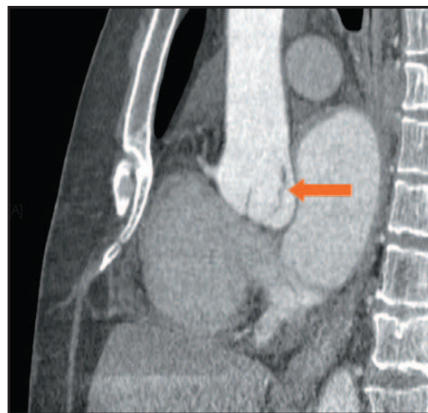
A cardiac CT angiographic image (sagittal view) shows the large, long aortic valve vegetation (arrow).
